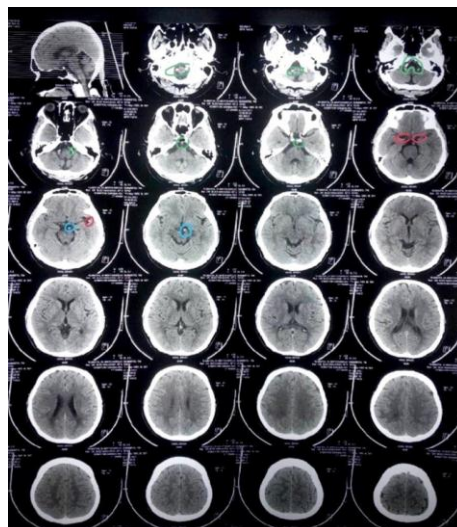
Non-contrast CT scan parenchymal window. Atherosclerosis features, green = vertebrobasilar (+ suspected left vertebral stenosis), red = middle cerebral artery, blue = posterior cerebral artery
